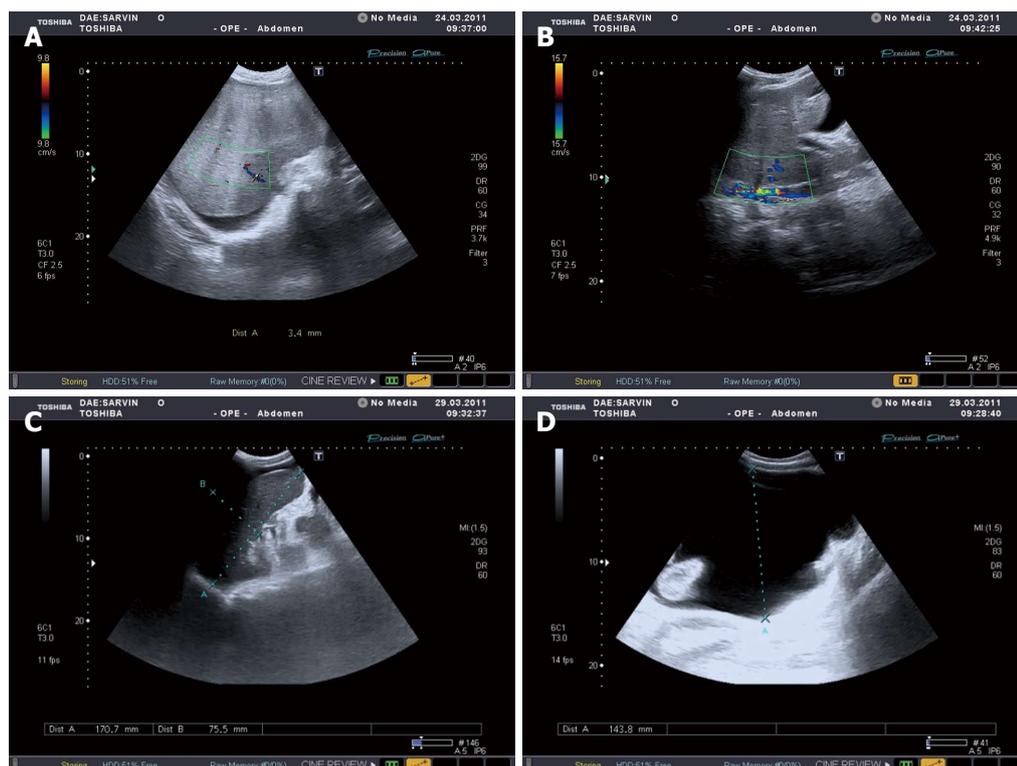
Ultrasound Doppler examination: Liver with signs of cirrhotic changes and luminal occlusion of hepatic veins to 3.4 mm (A); Non-occlusive thrombosis of retrohepatic segment of the inferior vena cava (B); Signs of portal hypertension development: ascites (C) and splenomegaly (D).
